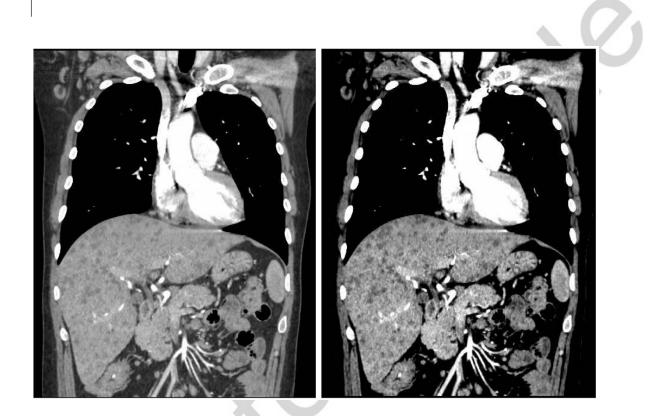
Computed tomography image showing multiple millimetric hypovascular liver lesions, sparing vascular structures and biliary tract.
